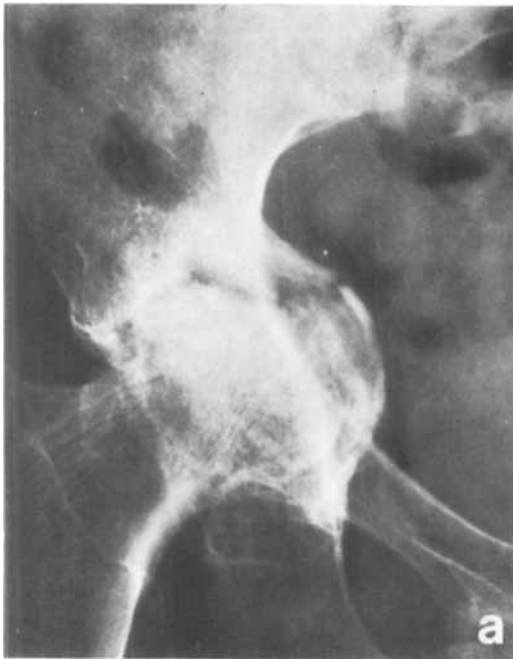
(Case 14). Rheumatoid arthritis. a. Radiograph of the pelvis shows protrusion of the right acetabulum and a fracture. b. CT scan at the acetabular level reveals fragmentation and thinning of the medially protruded acetabulum. Note cystic changes in the femoral head and the fracture of the anterior acetabular rim. These features are not demonstrated adequately by the plain radiograph.
